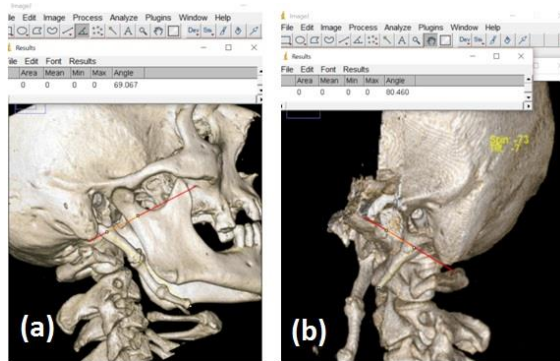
Multidetector computed tomography images; a, b. Three-dimensional (3D) of computed tomography (CT) scan shows length measurement and Type 3 ESP according to Langlais classification.
